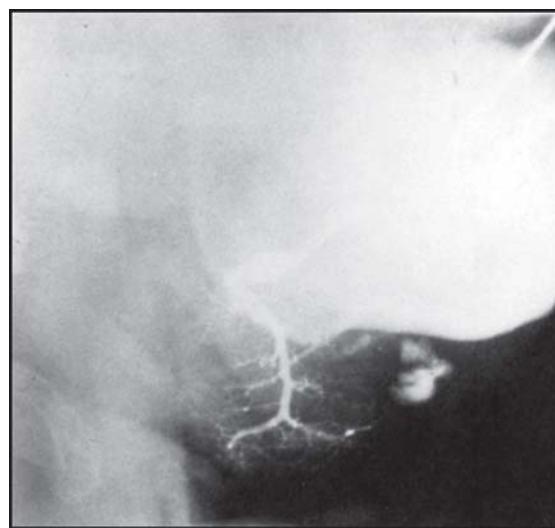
Radiographs are two-dimensional representations of three-dimensional objects. Slight rotation of the patient's head demonstrates that the calcification lies well beyond the boundary of the gland, which other wise could have appeared as calcifications in the submandibular region are superimposed over the gland
